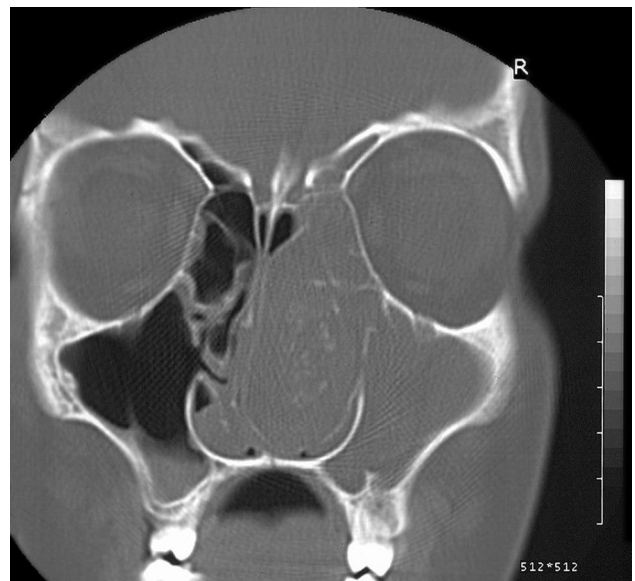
Coronal paranasal sinus computed tomography demonstrating a giant middle concha at the right side with calcified foci.
